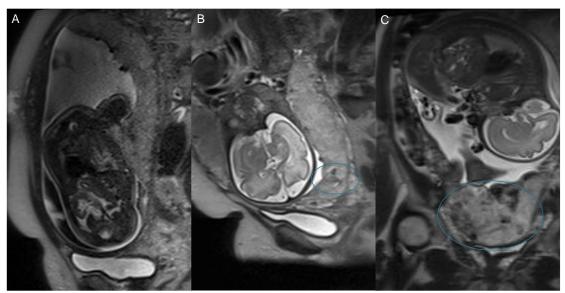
MRI images of normal (A) homogenous placenta, atypical placenta (B) with a single dark band, and the rest of the placenta normal and invaded placenta (C) with multiple dark bands and marked heterogeneity.
